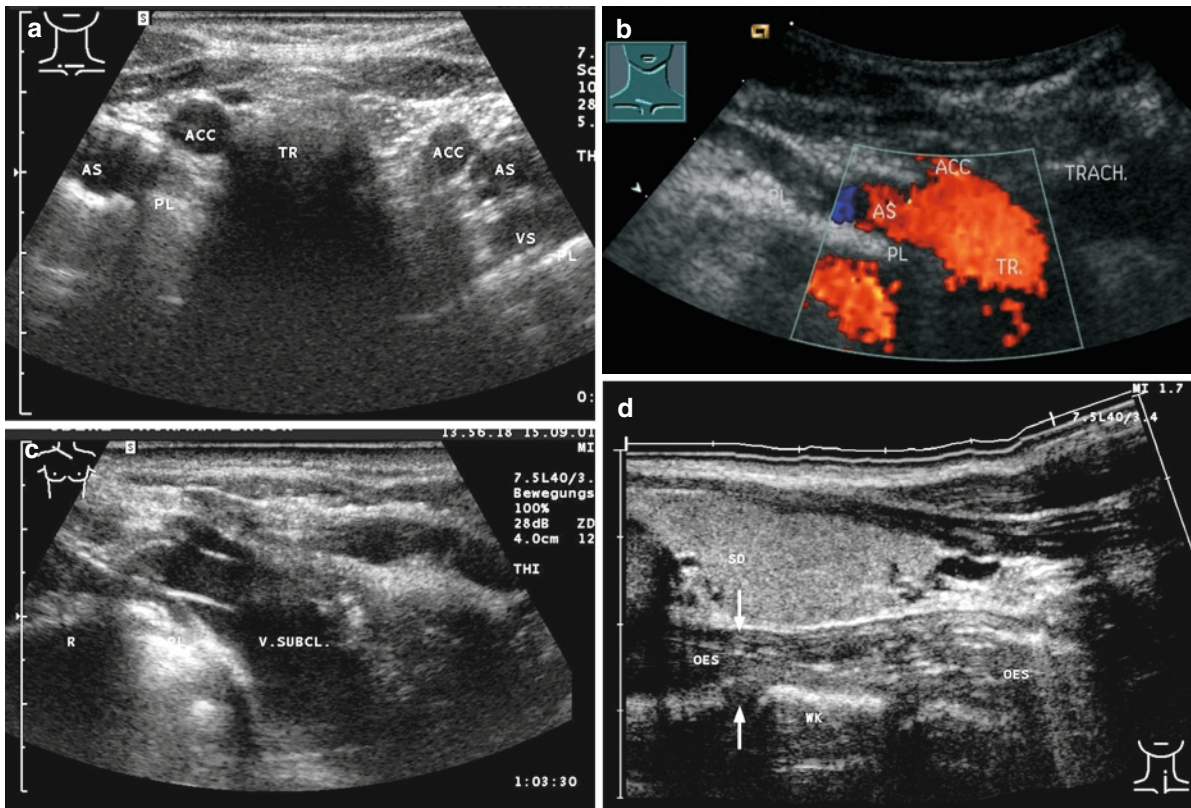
Suprasternal examination. The ultrasound head is located in the jugular fossa; there is a cushion under the shoulders and the head is reclined at the maximum angle
